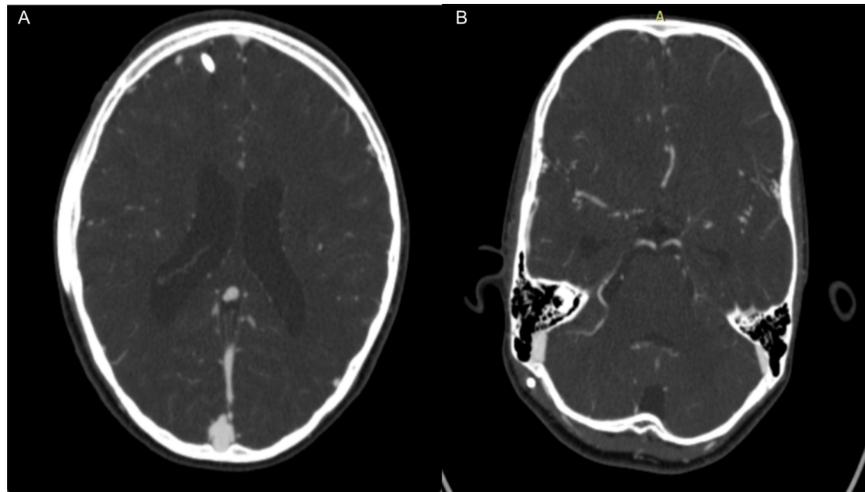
and 2B: CT angiogram taken after resolution of bleed 2 months after discharge
